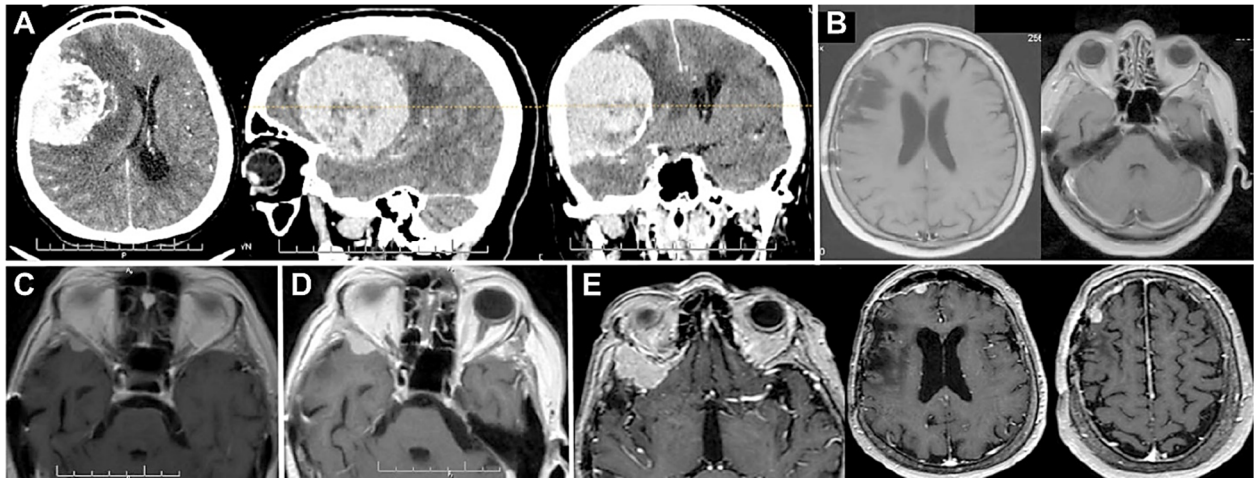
Recurrence of atypical meningioma: (A) Axial sagittal coronal contrast-enhanced CT showing a right pterional meningioma with strong and heterogeneous enhancement in a 58-year-old man; (B) Postoperative axial contrast-enhanced T1W MRI at 12 months showing absence of recurrence; (C) Axial contrast enhanced T1W MRI showing recurrence at 36 months, (D) at 48 months, and (E) at 60 months. Also, in the image (E) it can be observed the appearance of distant tumor nodules at 60 months after surgery. CT: Computed tomography; MRI: Magnetic resonance imaging; T1W: T1-weighted.
